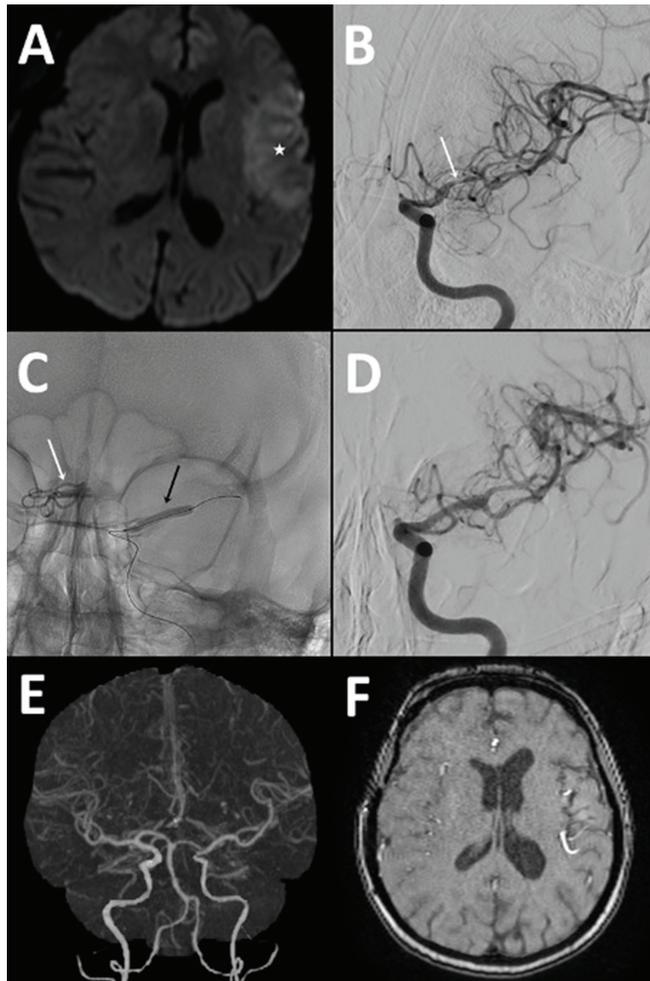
A 50-year-old female patient who underwent surgery due to an artery aneurysm in the hemorrhaging anterior communicating segment (Acom). A. Diffusion magnetic resonance imaging (MRI) was performed for the patient on the postoperative sixth day after the development of aphasia and paresis in the right upper limb. Image of an acute ischemic area (star) causing diffusion restriction in the watershed area of the left middle cerebral artery (MCA) in the left parietal region. B. Anterior-posterior image from preoperative digital subtraction angiography showing significant vasospasm in the left MCA (arrow) and slowed flow in the distal branches. Upon this finding, 2 mg of intraarterial nimodipine was administered to the patient. C. Upon the patient showing no response to nimodipine, balloon angioplasty was performed on the left MCA M1 segment with a compliant balloon of 4×20 mm (black arrow). Image shows clip material (white arrow) in the Acom arterial area. D. Anterior-posterior control image showing that the vasospasm was completely eliminated and the flow in the distal branches returned to normal. The patient's aphasia and paresis of the right upper extremity improved. E. Three-dimensional anterior-posterior computed tomography brain angiography image taken 1 year later showing that the left MCA and its branches have normal width and correct location. F. Axial section of MRI angiography performed 1 year later showing no infarct areas
